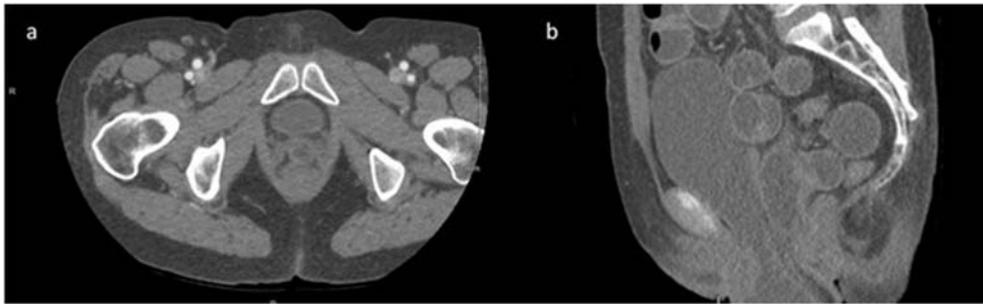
Axial and coronal CT imaging of patient with (a) loops of bowel in vaginal vault and (b) dilated loops of bowel leaving the pelvis.
